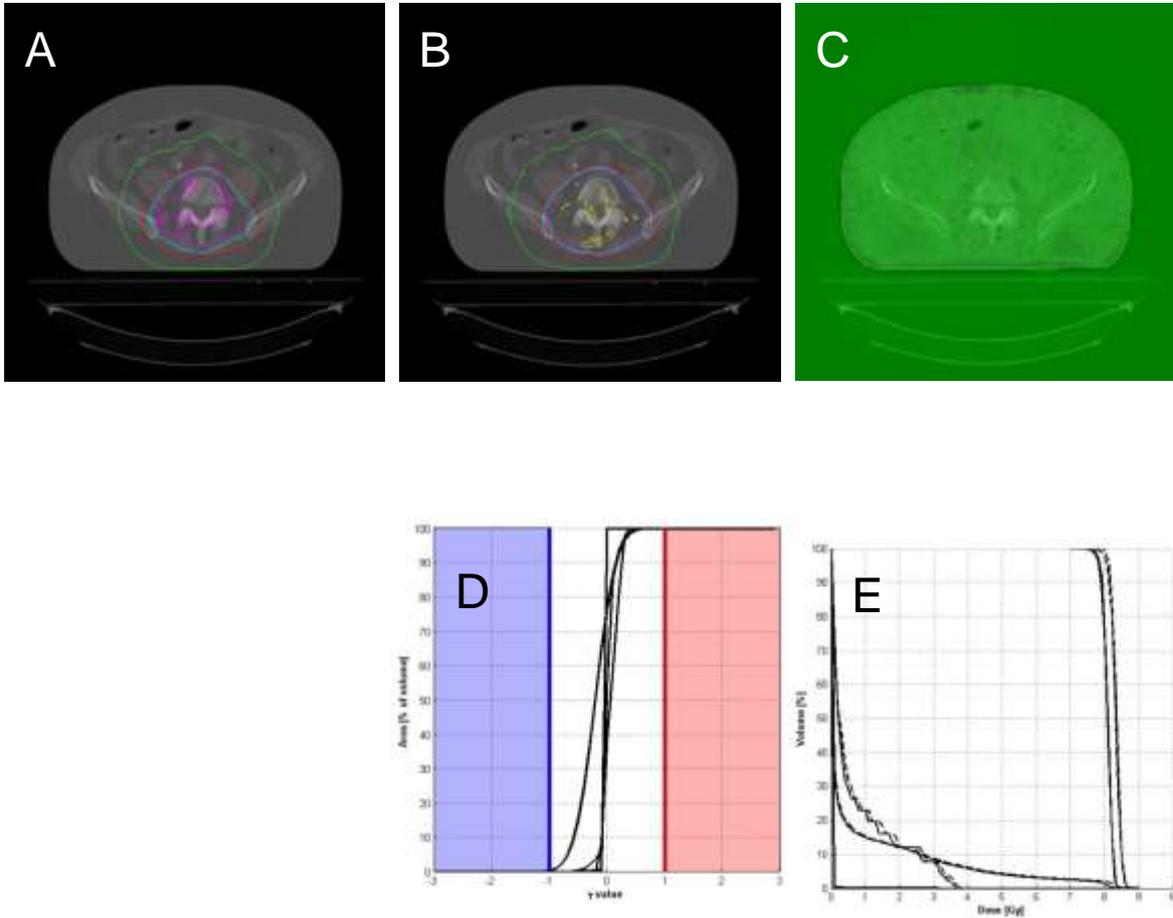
(A) 3D dose distribution from the TPS (Eclipse, Varian Medical Systems, Palo Alto, CA, USA) for the same VMAT treatment technique as applied in figure 1. (B) 3D reconstructed dose distribution based on pre-treatment EPID dose measurements and reconstructed in the planning CT scan. (C) Comparison of the two 3D dose distributions in (A) and (B) by using a 3D gamma evaluation with global gamma criteria of 3% and 3 mm. (D) Cumulative gamma histograms and (E) cumulative dose-volume histograms for different volumes delineated in the TPS.
